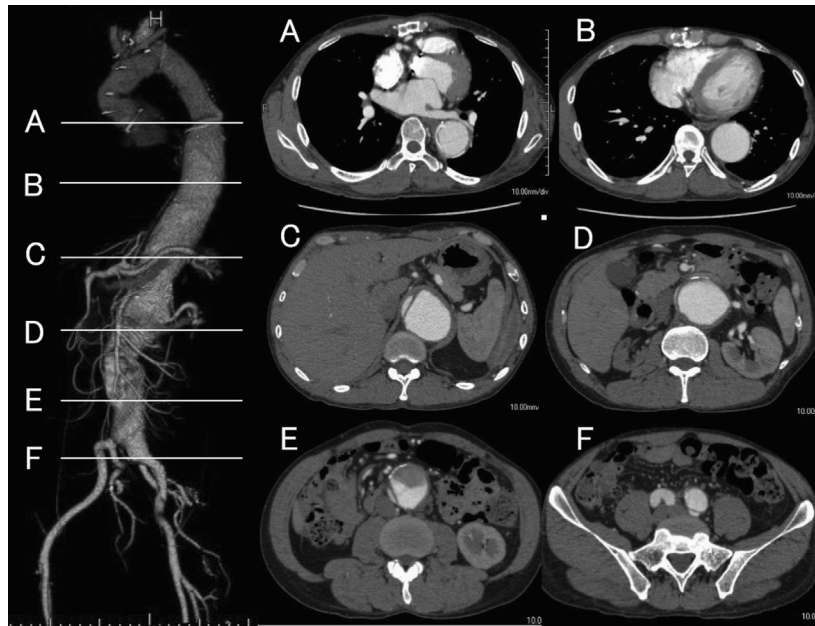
Preoperative computed tomography angiogram (CTA) shows aortic dissection extending from the double-barrel anastomosis of the previous surgery to the left common iliac artery (LCIA) with a very narrow true lumen. The right renal artery shows narrowing with renal atrophy because of low blood flow. A, The level of anastomosis; B, the midthoracic aortic level; C, the celiac trunk level; D, the left renal artery level; E, the midabdominal aortic level; F, the common iliac artery level.
